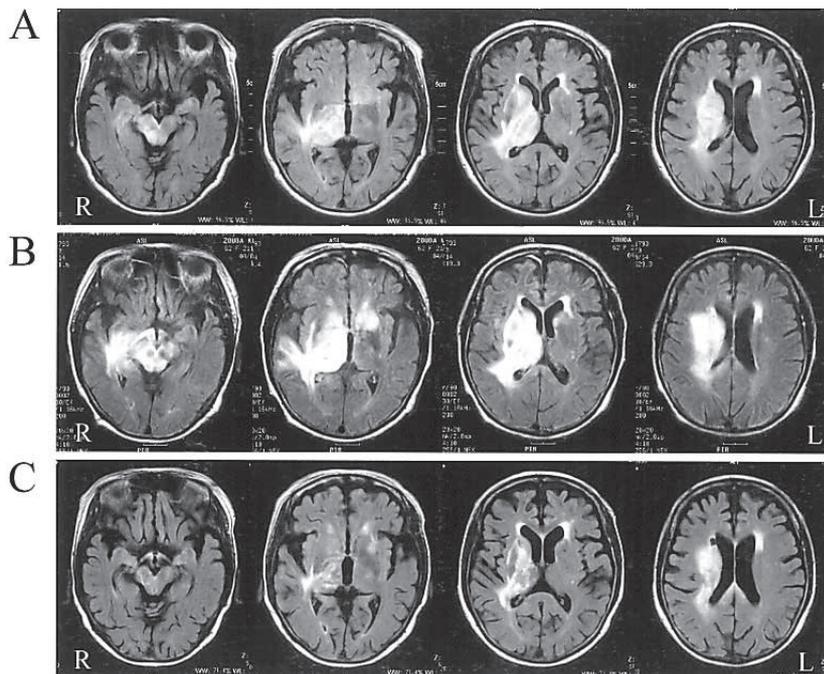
MRI on admission to our department. FLAIR images showed high-intensity areas in the right basal ganglia, periventricular white matter and brain stem, which were similar to those obtained at the previous neurosurgical clinic (A). Two weeks later, FLAIR images demonstrated enlargement of the high-signal lesions (B). After the first course of chemotherapy, FLAIR images showed reduction of the lesions (C). These changes were well associated with her neurological findings.
